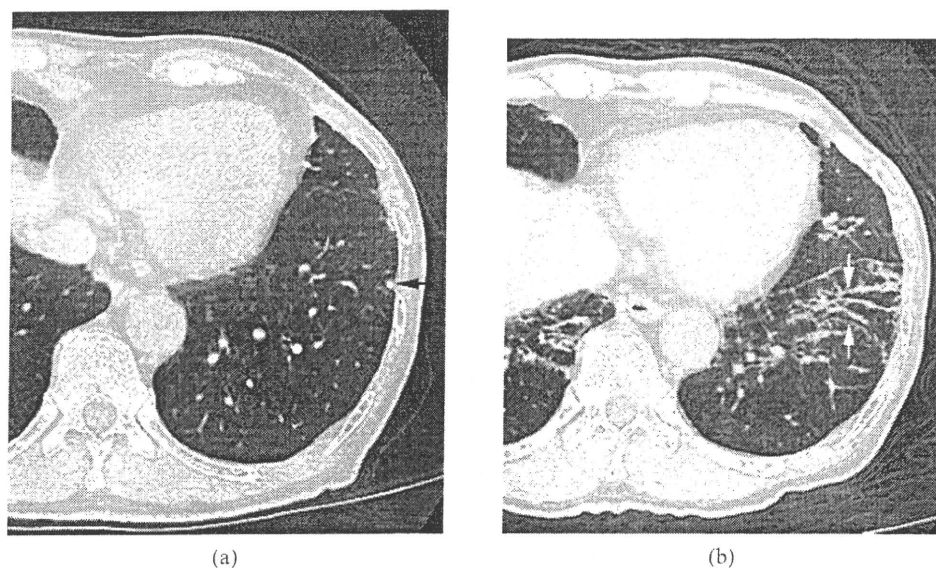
Image in a 69-year-old man. (a) Transverse CT scan (1 mm section thickness) obtained at the level of left lower lobe shows a nodule in the periphery (arrow; KL-6, 333 U ml⁻¹). (b) Transverse CT scan (1 mm section thickness) obtained 6 months later shows architectural distortion (KL-6, 581 U ml⁻¹). Traction bronchiectasis is also present (arrows).
